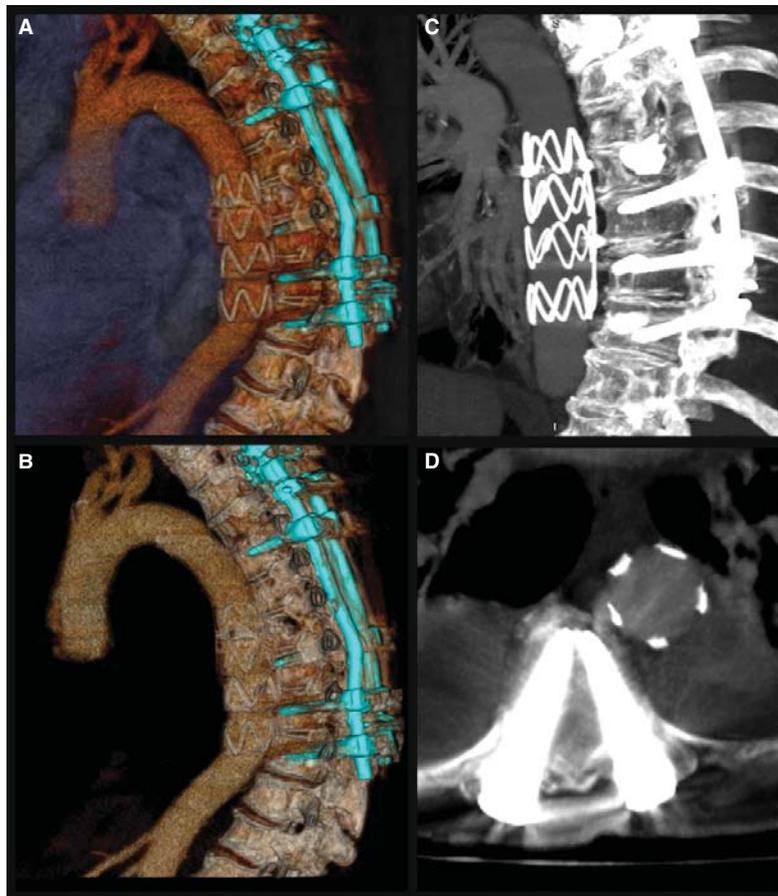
(A-B) Angiography computed tomography three-dimensional reconstructions showing patency of the stent-graft and the thoracic aorta. (C-B) CT Multiplanar reconstruction in lateral (C) and axial (B) view showing the relationship of the aorta and stent-graft with osteosynthesis screws and indemnity aortic wall without associated injuries.
